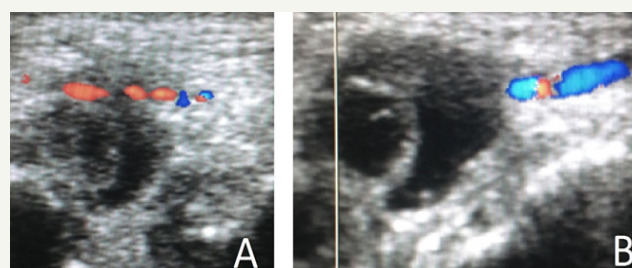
Ultrasonography with Doppler in A and B demonstrating pseudoaneurysm with thrombosis in the distal radial artery.
